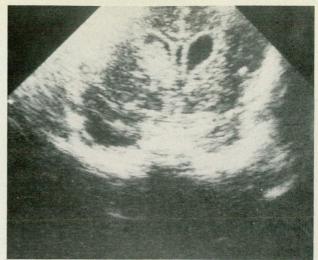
and 1B are examples of normal (grade O) ultrasonograms. Figs. 2A-2G depict SEH with IVH and ventricular dilatation (grade III ICH), and Figs. 2H and 2I demonstrate typical grade IV ultrasonographic findings. Extensive choroid plexus ICH with primary IPH extension is portrayed in Figures 3A and 3B.
